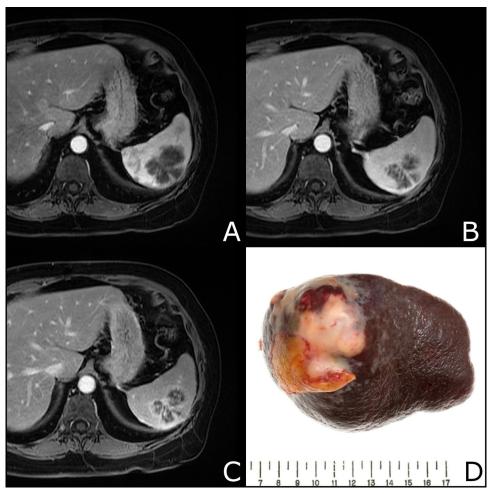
Multi-phase magnetic resonance imaging (MRI) at 1, 5, and 10 minutes (A, B, and C, respectively) showing a multi-lobulated, non-vascular 3.5×4.9 cm progressive heterogeneous enhancement in the spleen. (D) A section of the resected spleen showing the primary splenic diffuse large B-cell lymphoma lesion.
